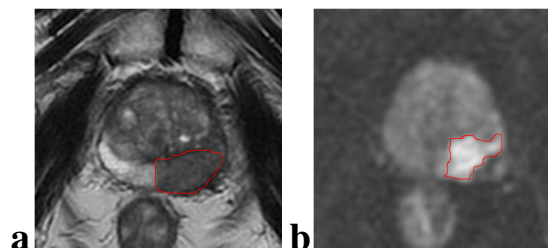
Multi-parametric MR images of a typical PCa patient, where the red outlines are the most suspicious regions of PCa. a) T2WI; b) DWI ($b = 800 \text{ s/mm}^2$).
